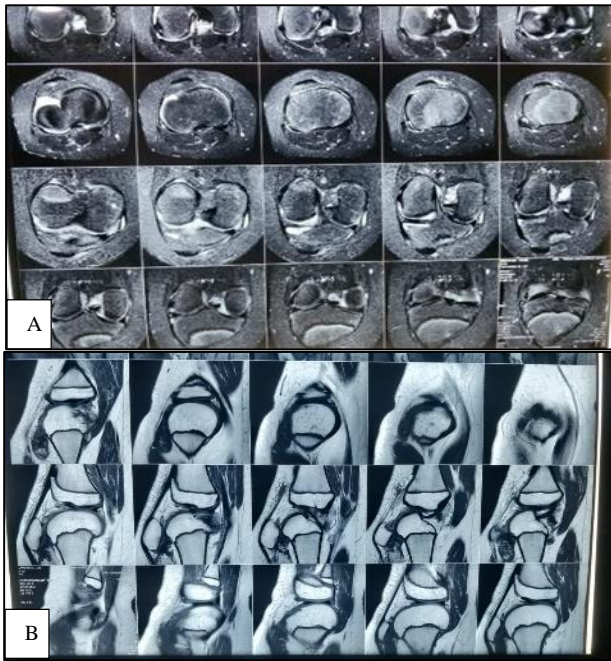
(A and B): MRI right knee (axial and sagittal sections) of villonodular inflammatory changes of synovium.
